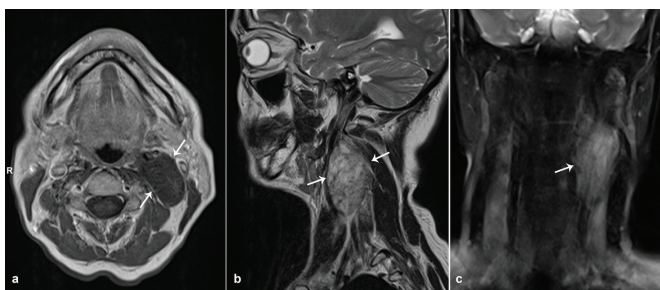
Magnetic resonance imaging. a) Isointense image of the mass in T1 sequence axial section, b) hyperintense view of the mass in T2 sequence sagittal section, c) T2 sequence coronal section
